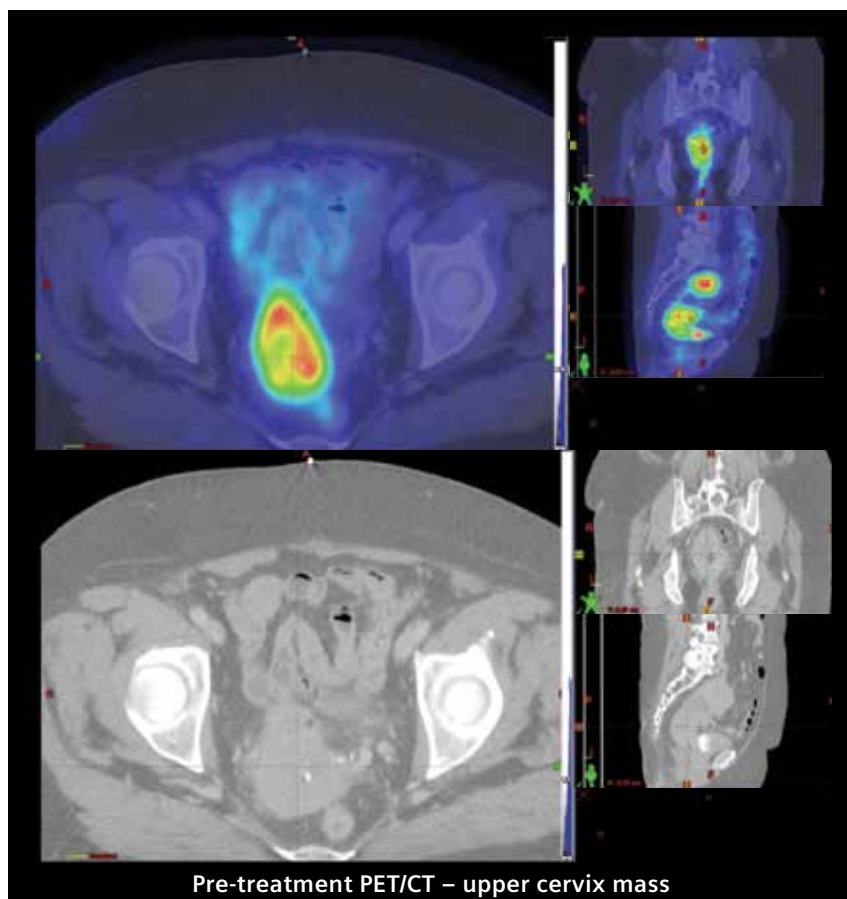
Pre-therapy PET/CT images at the level of the upper cervical tumor mass shows increased tracer uptake in the mass with slightly decreased uptake in the center.
